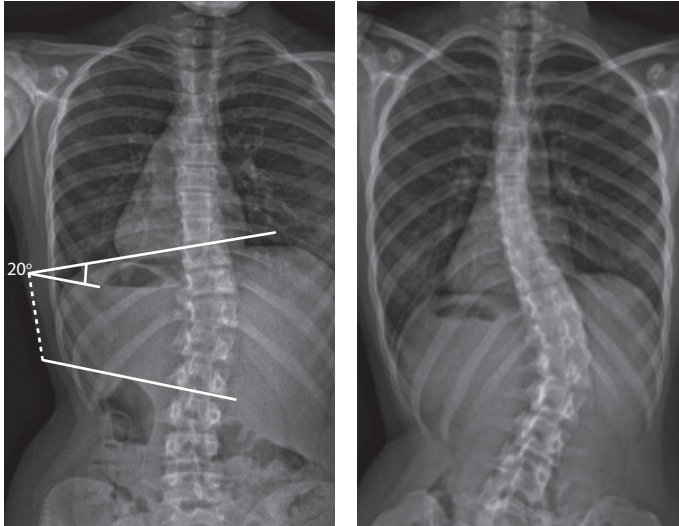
Examples of X-rays of spines with scoliosis.
